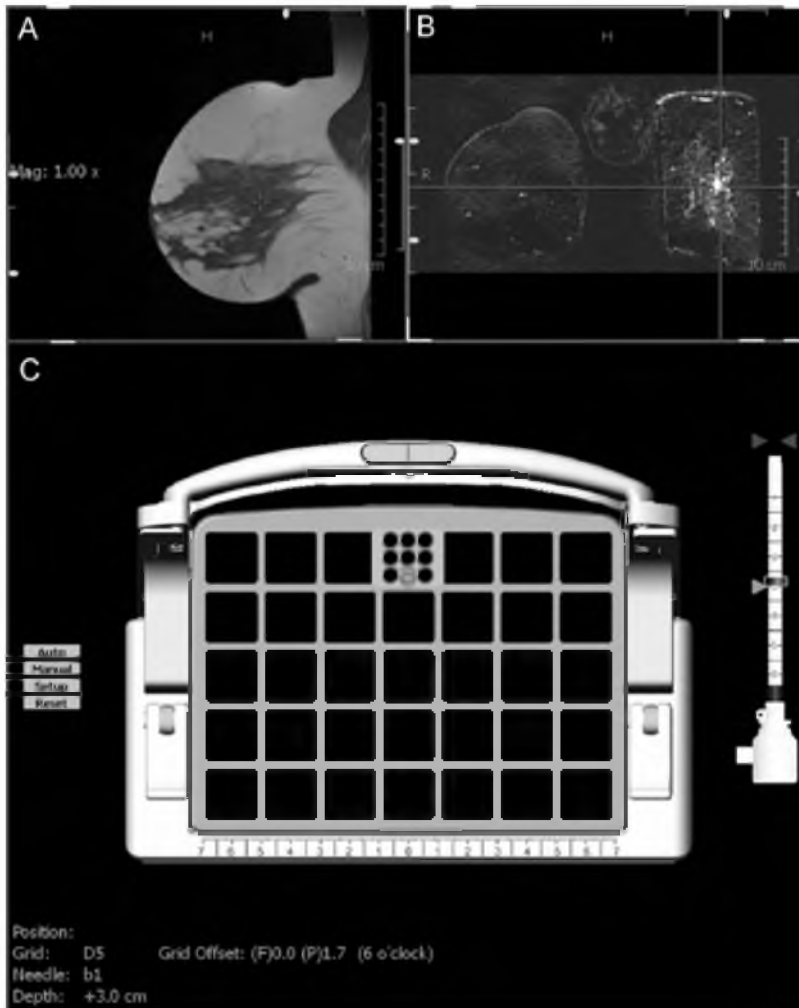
MRI geleide mamma biopsie van een multifocaal ILC in de linker mamma, na negatieve mammografie en niet geslaagde echografische lokalisatie. Er wordt gebruik gemaakt van een computer programma (DynaCAD, Invivo, Orlando, USA) om de naald accuraat te positioneren. Bij A is een native sagittale T1 opname van de linker mamma zichtbaar, de naald is op dit moment gericht op de cursor. Bij B is een coronaal subtractie beeld van beide mammae afgebeeld, waarop de laesie wordt gelokaliseerd. De laesie bevindt zich midden tussen de kruisende lijnen. Bij C wordt de biopsie grid afgebeeld. Er is zichtbaar waar het naaldgeleider blokje moet worden gepositioneerd (paarse blokje met rondjes) en welk van de gaten gebruikt moet worden voor de biopsie (gele cirkel) om zo dicht mogelijk bij de optimale biopsie plaats (rode cirkel) te komen (zie hoofdstuk 10 voor een afdruk van dit figuur in kleur). De noodzakelijke biopsie diepte kan worden afgelezen aan de onderzijde van het scherm. Met gebruik van vacuüm biopsie is ongeveer 95% van de biopten conclusief
